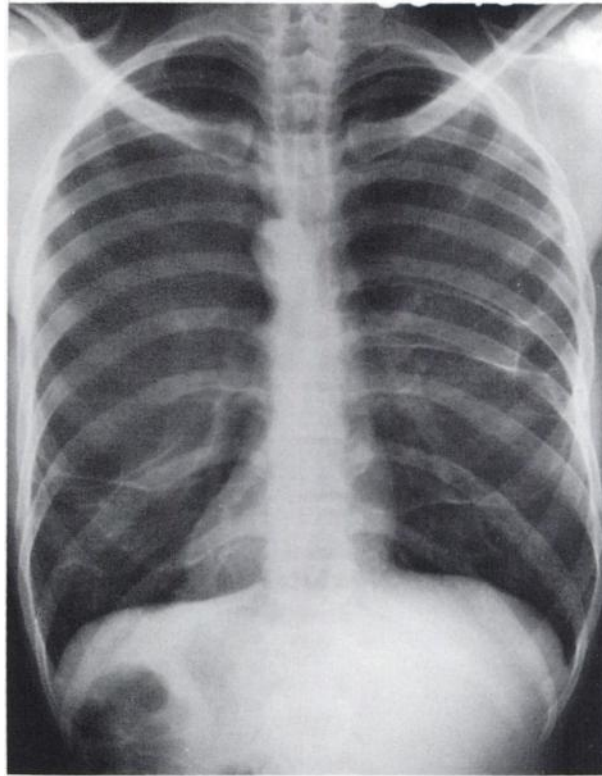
Chest roentgenogram on patient W.L.H. with bullous emphysema. Left lung is on the viewer's left to correspond with scanning data.
